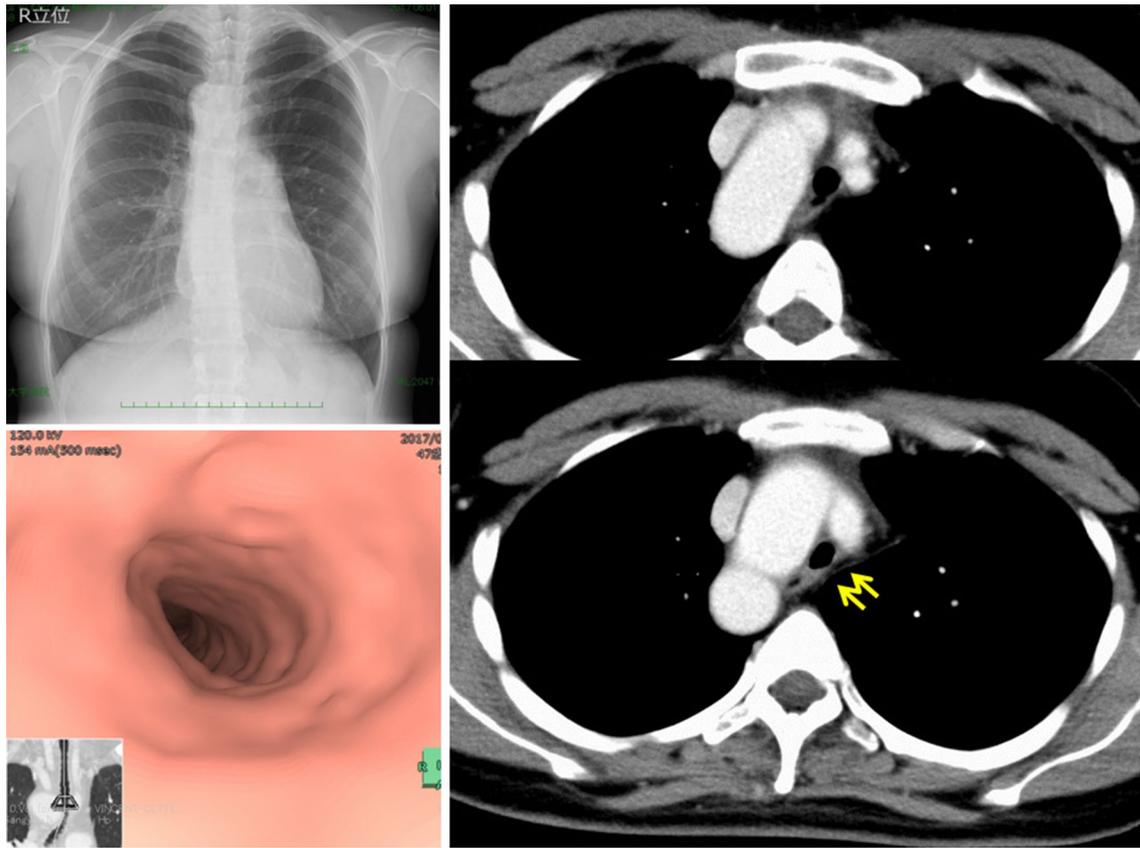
Chest (left upper) roentgenogram showed right aortic arch. Chest computed tomography (right) revealed severe compression of trachea and esophagus by right aortic arch and a bundle structure
